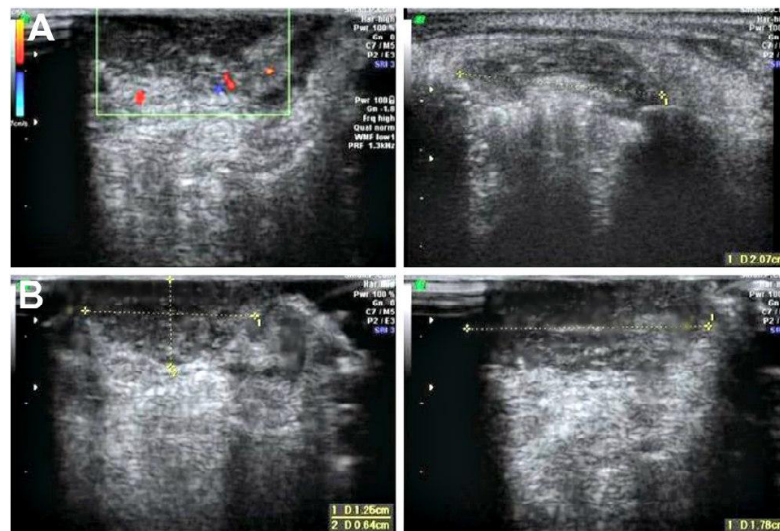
Ultrasound Colour Doppler of the right cheek performed A One month after Sclerotherapy; and B Two months after sclerotherapy, showing reduction in size of the hypo-echoic region as well as diminished vascularity within it, indicative of successful resolution of the VM.
